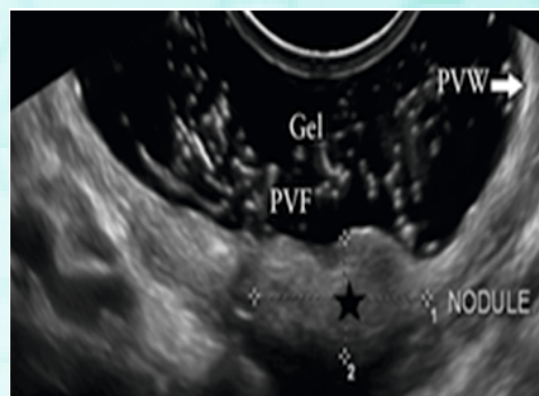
Gel vaginosonography to improve detection of DIE. (PVW- posterior vaginal wall, PVF- posterior vaginal fornix)
